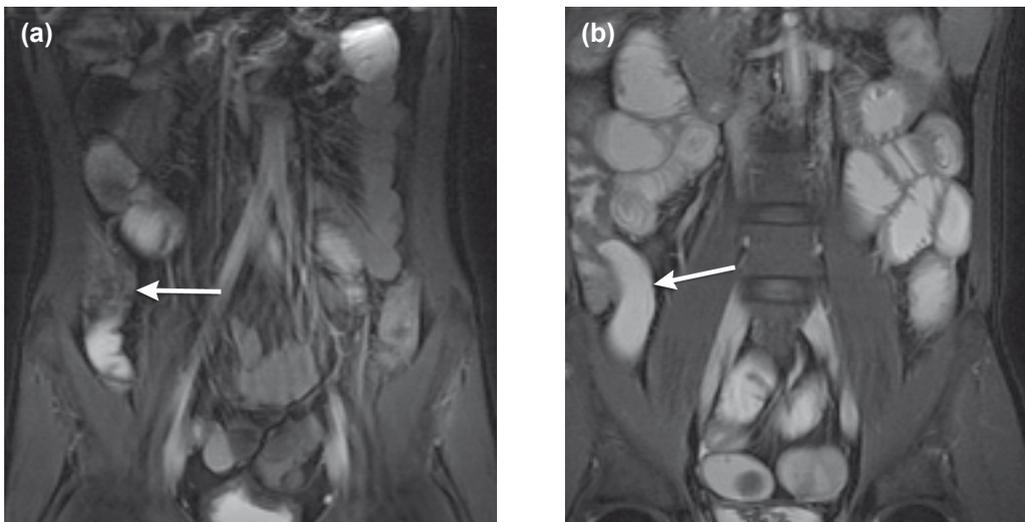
Twenty-eight-year-old male for whom MRI was performed to differentiate between Crohn's disease and ulcerative colitis. (a) Coronal true FISP fs shows collapsed terminal ileum (arrow). Small bowel wall thickening cannot be excluded. (b) Coronal true FISP fs shows optimal distended terminal ileum (arrow), without bowel wall thickening. No small bowel pathology was detected elsewhere. This patient was diagnosed with ulcerative colitis in follow-up.
